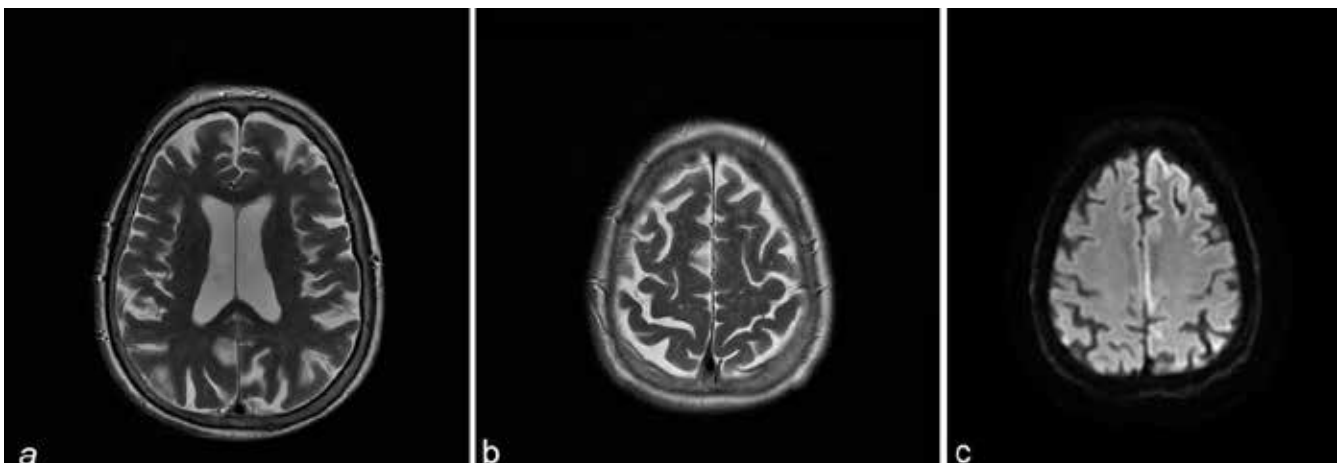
a, b T2-weighted MRI showing dilatation of the lateral ventricle, diffuse cerebral atrophy, and high-intensity areas in the cerebral white matter. c DWI indicates high signal intensity areas, particularly in the frontal, parietal, and occipital cortices.
